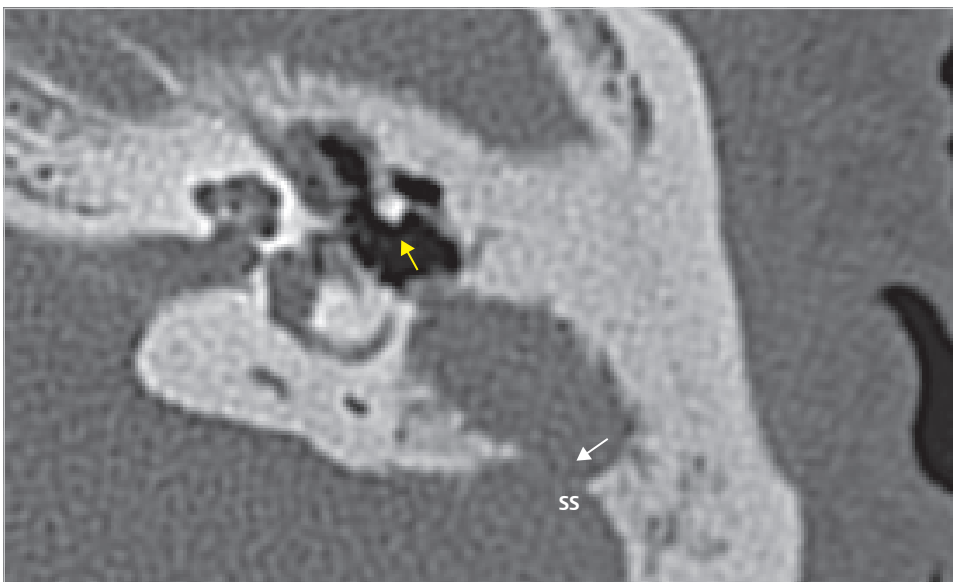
The preoperative CT demonstrates cholesteatoma located lateral to the remnant of the malleus (yellow arrow), loss of the incus in the attic, and soft tissue density in the antrum eroding the bone covering the sigmoid sinus (white arrow). SS, sigmoid sinus.
